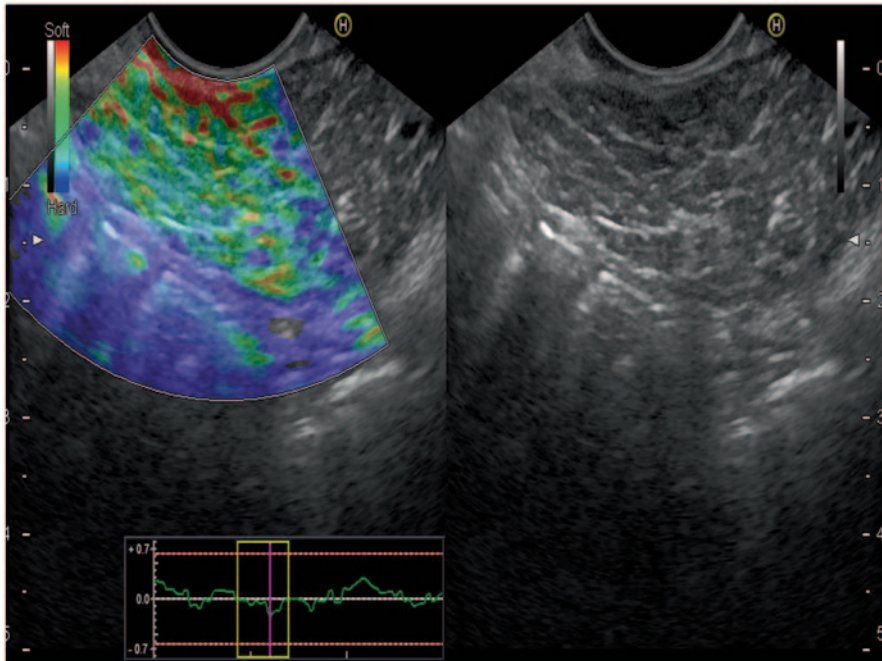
Typical conventional EUS (*right*) and EUS elastography (*left*) images of the chronic pancreatitis. The color map of chronic pancreatitis is more heterogeneous than that of normal pancreatic parenchyma which is shown in Fig. 1. *EUS* endoscopic ultrasonography
